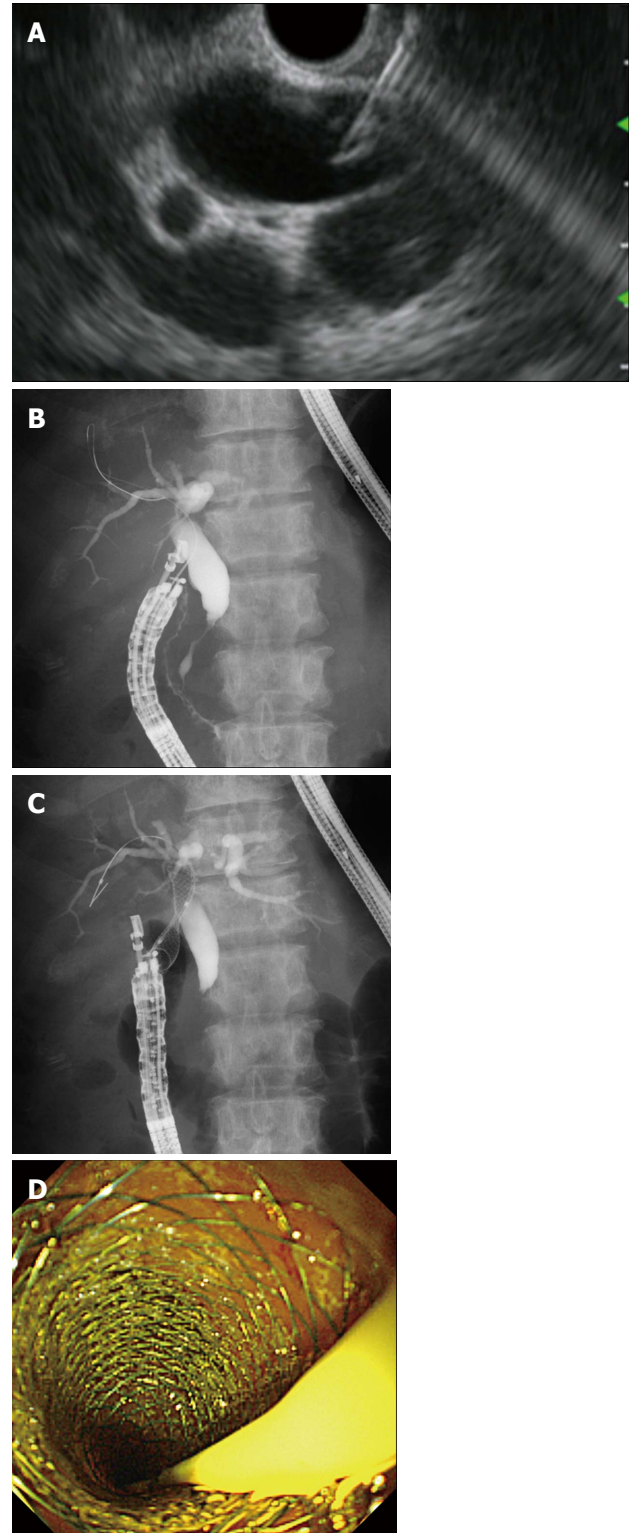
Endoscopic ultrasonography-guided choledochoduodenostomy. A: Endoscopic ultrasonography showing that extrahepatic bile duct was punctured by the needle; B: Guidewire was advanced through the needle into the right liver lobe; C: A self-expandable metallic stent (SEMS) was placed between the bile duct and the duodenum; D: Endoscopic view showing that the distal end of a SEMS was located at the duodenum.
